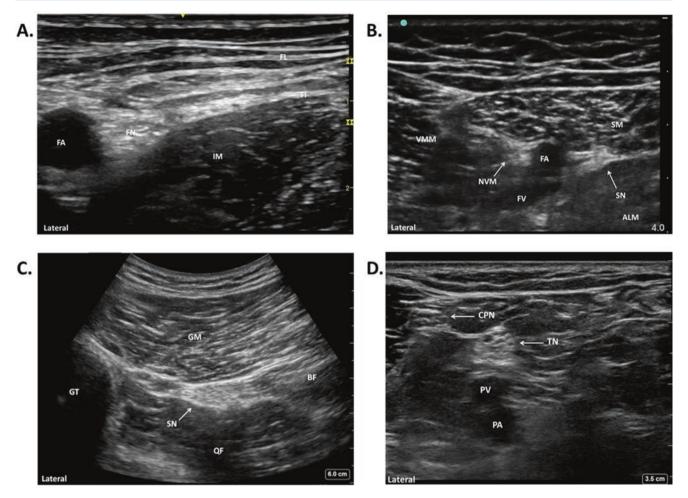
Ultrasound images of anatomy for lower extremity nerve blocks (A.) Femoral nerve block. The femoral nerve (FN) is lateral to both the femoral artery (FA) and femoral vein (FV). FA femoral artery, FI fascia iliac, FL fascia lata, FV femoral vein. (B.) Adductor canal block. The adductor canal lies deep to the sartorius muscle (SM), medial to the vastus medialis muscle (MVV) and superior lateral to the adductor muscles. It contains the branches of the femoral vessels, the saphenous nerve (SN), and the nerve to vastus medialis (NVM). SM sartorius muscle, VMM vastus medialis muscle, FA superficial femoral artery, FV superficial femoral vein, NVM nerve to vastus medialis, ALM adductor longus muscle. (C.) Sciatic nerve block, subgluteal location.
